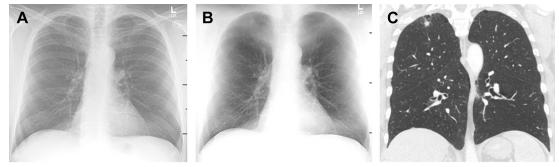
(A) PA chest radiograph shows a subtle right upper lobe nodule which is obscured due to overlying bone. (B) Dual energy chest radiograph with bone subtraction significantly improves the conspicuity of the right upper lobe nodule. (C) Coronal chest CT shows the spiculated right upper lobe nodule. This nodule was missed on the initial chest radiograph due to overlying osseous structures.
